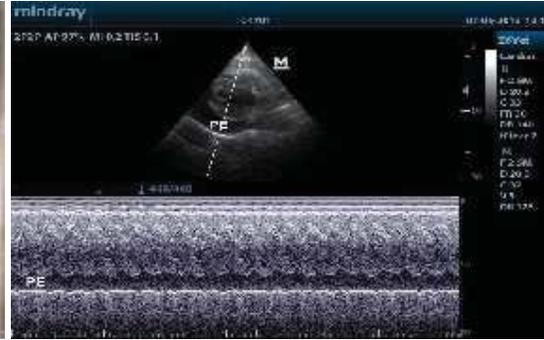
Pericardial effusion and cardiac tamponade- 2- dimensional and M-mode echocardiogram, PE- Pericardial effusion
